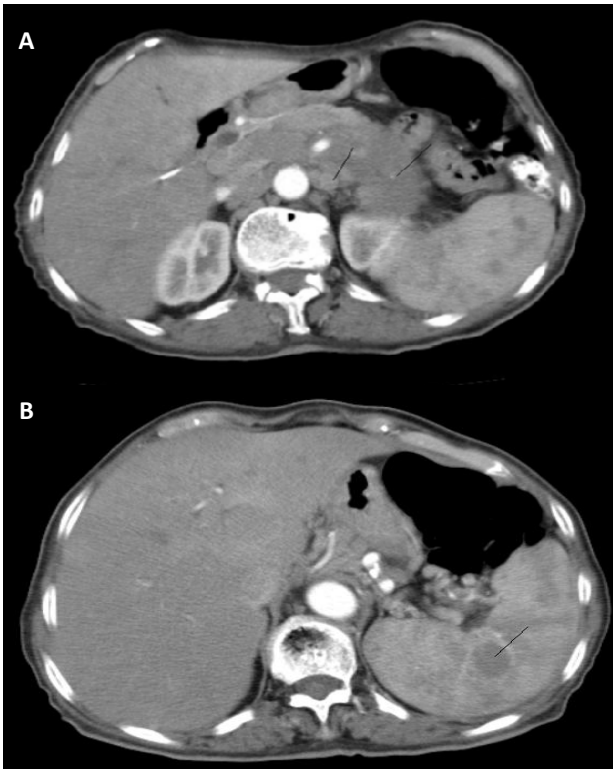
Axial CT scan before the Adriamycin, Bleomycin, Vinblastine and Dacarbazine chemotherapy: A) Showing pancreatic mass and a left para-aortic lymph node. B) Showing a splenic nodule which was 20 mm in diameter.
